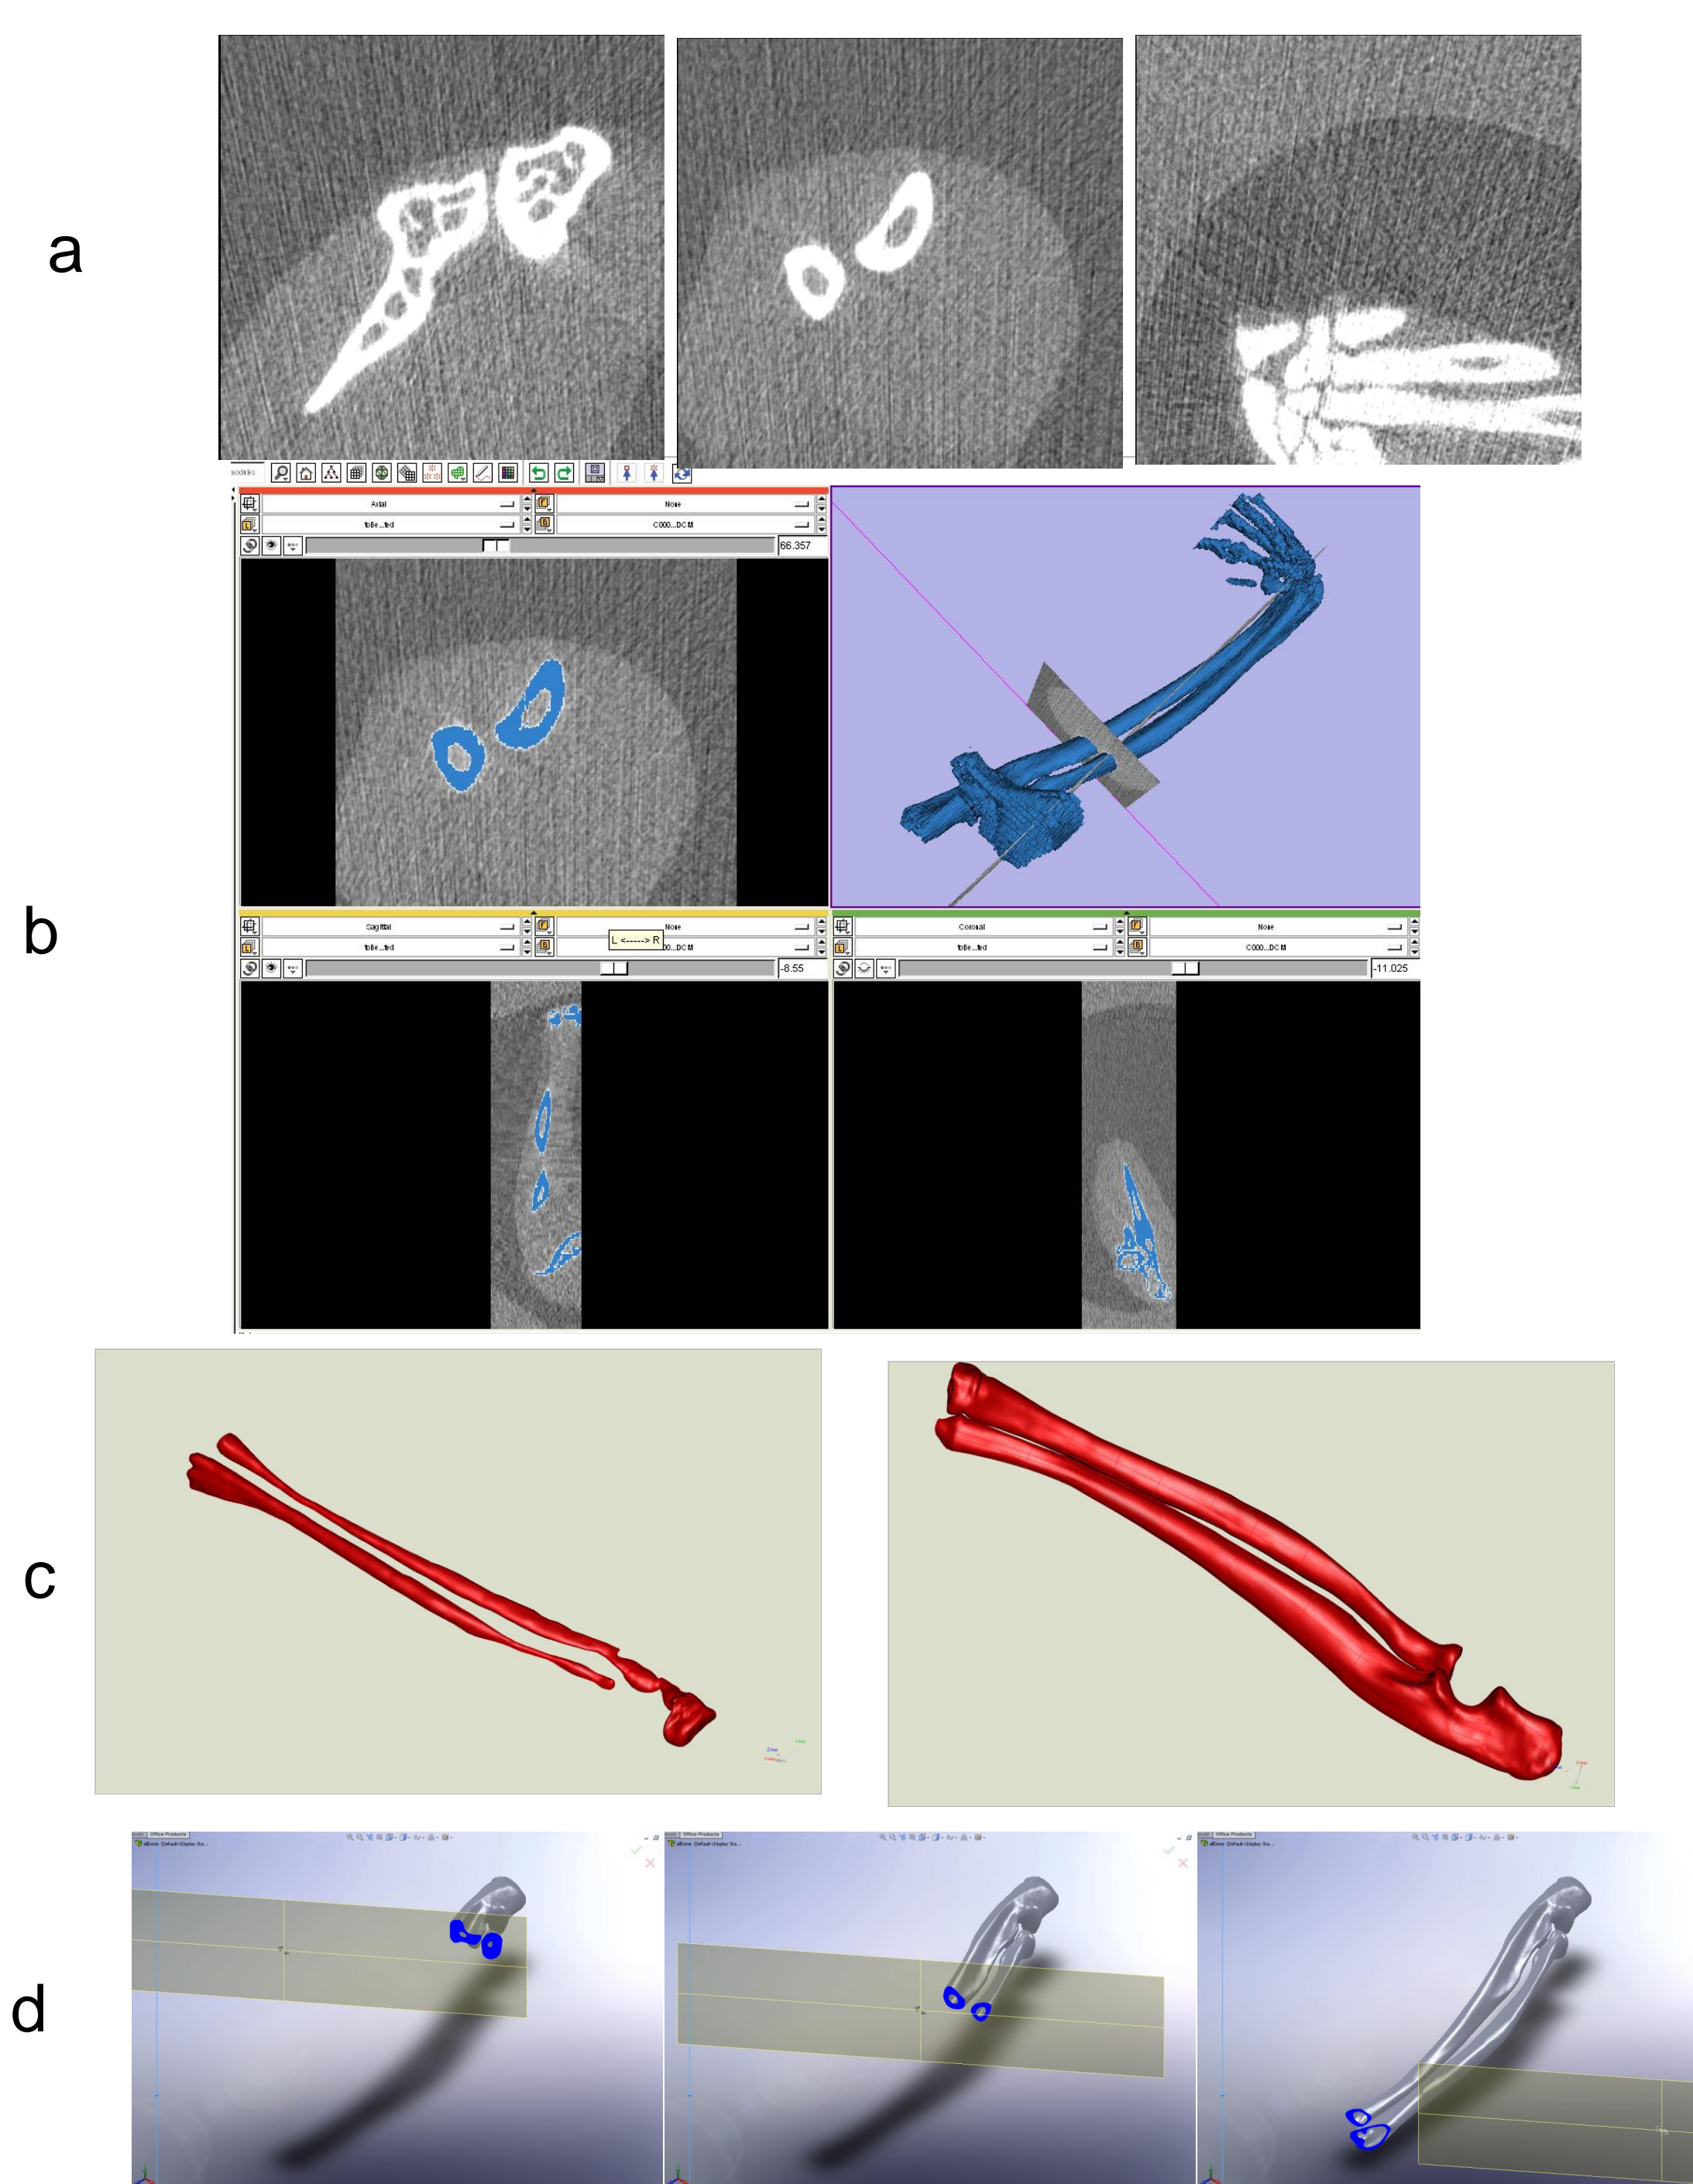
Modeling process (row a: selective  $\mu$ CT images; row b: image tracing; row c: final CAD model of cavities and ulna w/ radius; row d: selective sectional cuts revealing the cavities)
